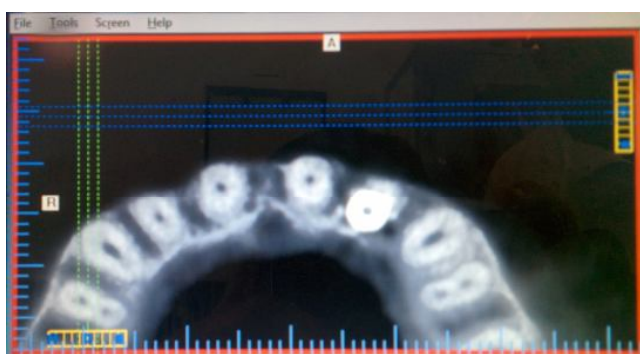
Post operative CBCT showing occlusal view of implant
